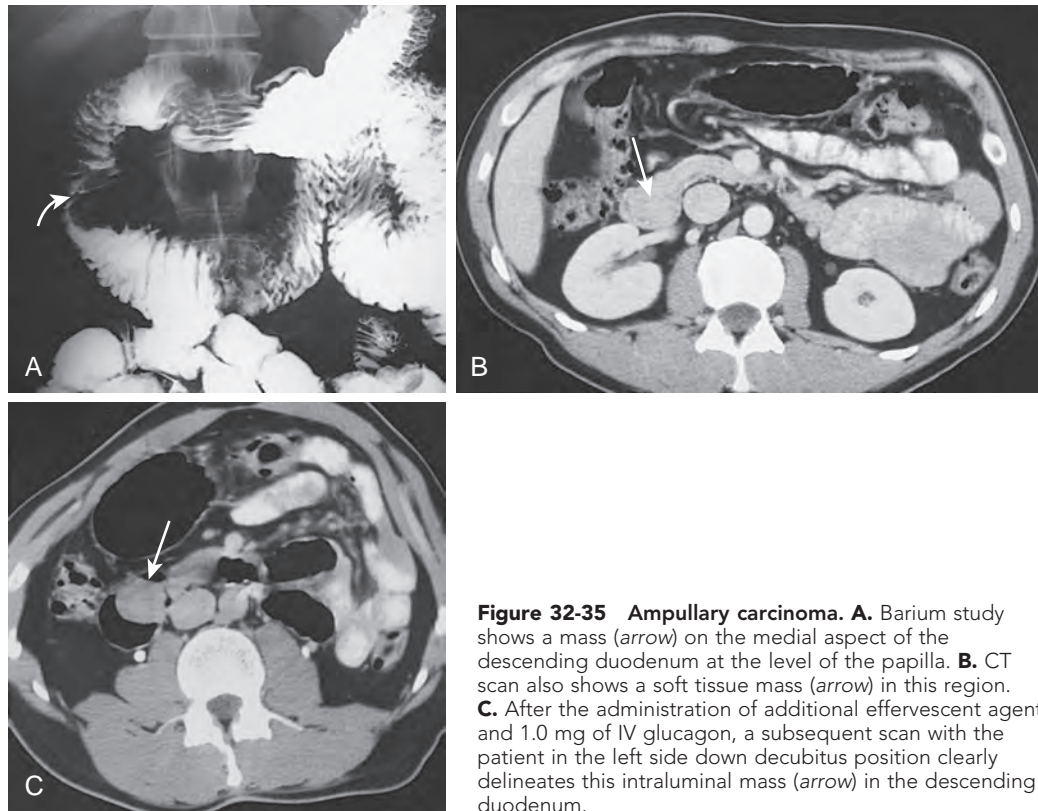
Ampullary carcinoma. A. Barium study shows a mass (arrow) on the medial aspect of the descending duodenum at the level of the papilla. B. CT scan also shows a soft tissue mass (arrow) in this region. C. After the administration of additional effervescent agent and 1.0 mg of IV glucagon, a subsequent scan with the patient in the left side down decubitus position clearly delineates this intraluminal mass (arrow) in the descending duodenum.
